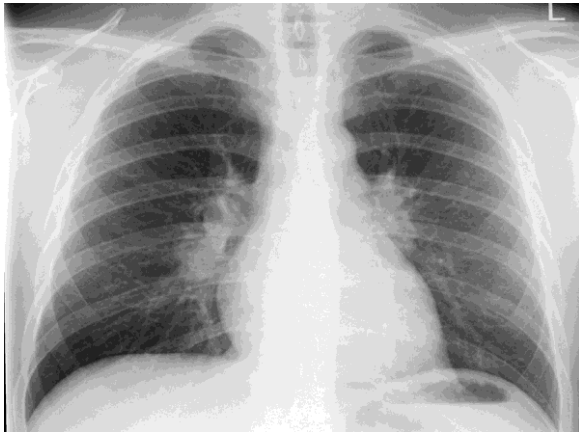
Chest X-Ray displaying characteristic bilateral hilar lymphadenopathy and reticulonodular opacities.
